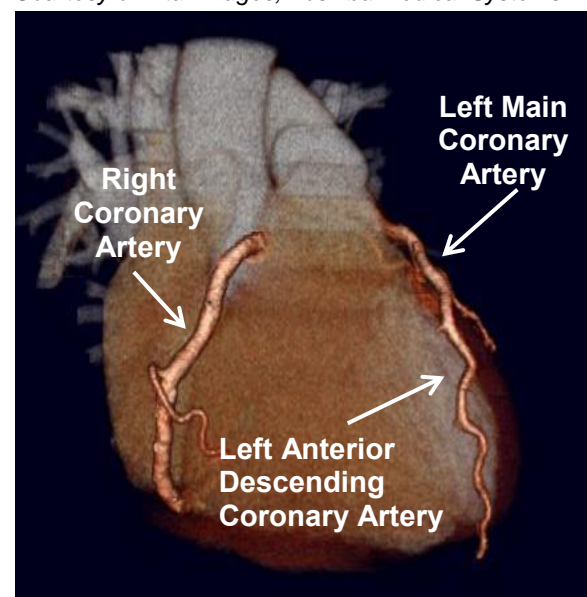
CT angiogram of coronary arteries.
